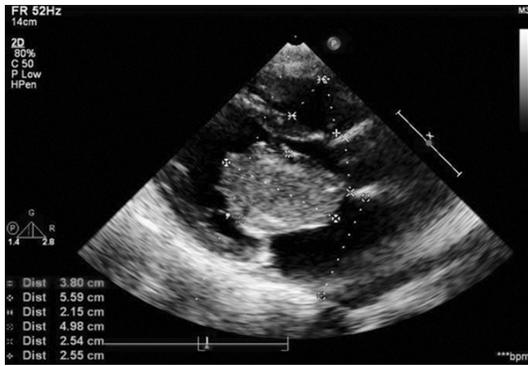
Preoperative 2D echocardiography.
